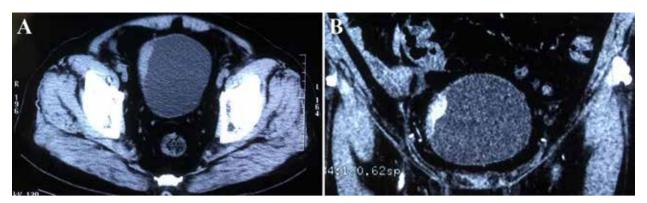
Computed tomography scans indicated a thickened right bladder wall and the tumor had spread into the deep bladder wall layer.
